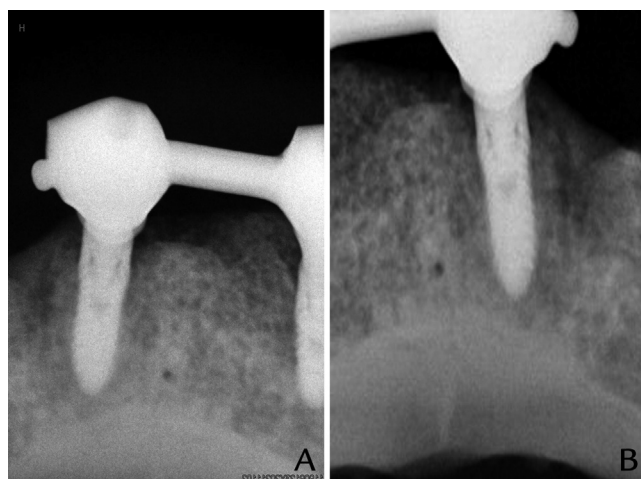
Representative postoperative periapical radiographs. A, Left implant. B, Right implant.
